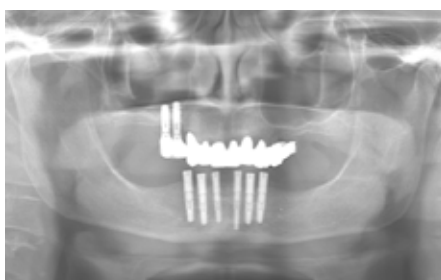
The postoperative x-ray check shows the proper position of the implants.
